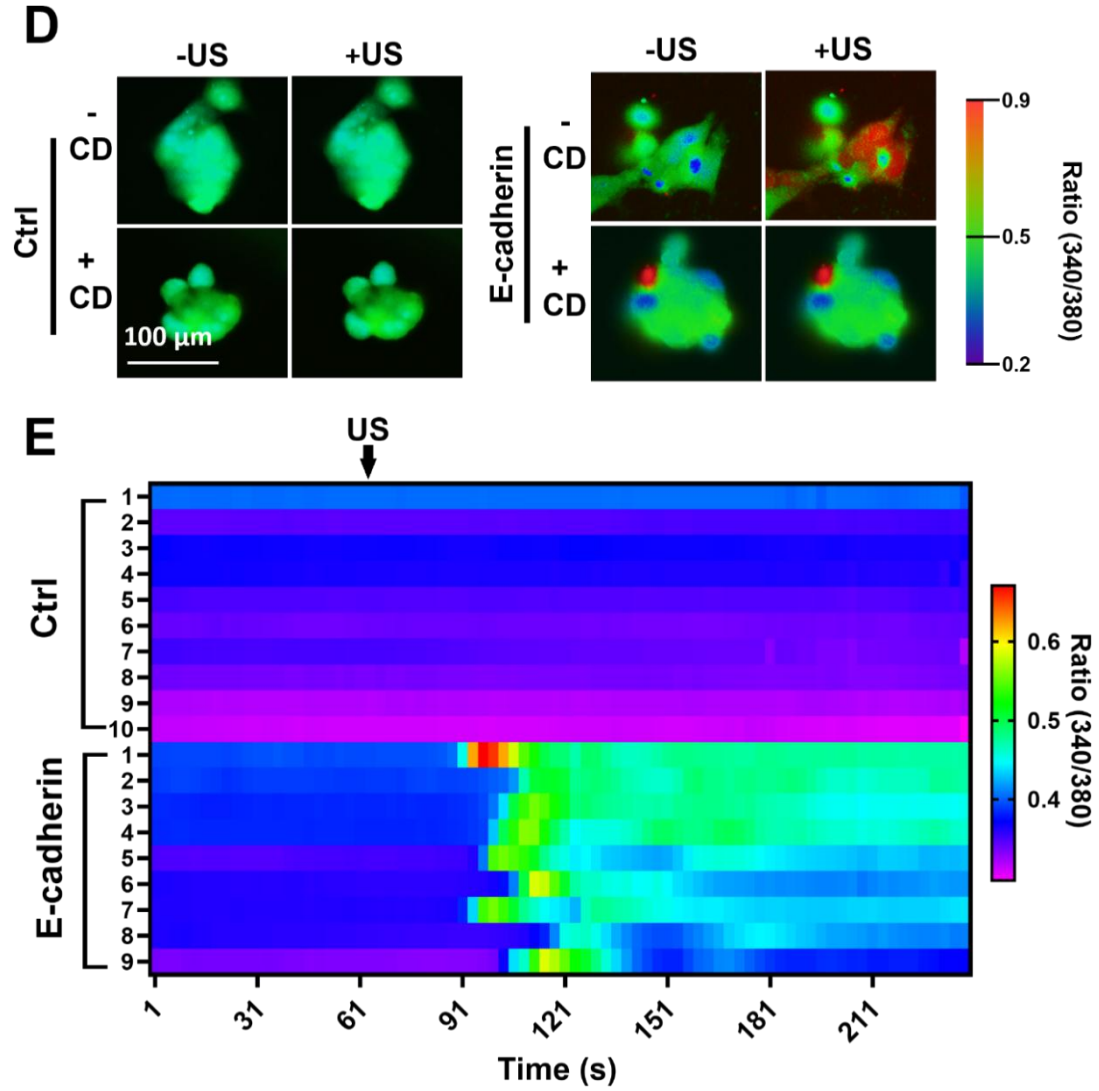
Non-ion channel protein mediate ultrasound-induced activation of 293T cells.
